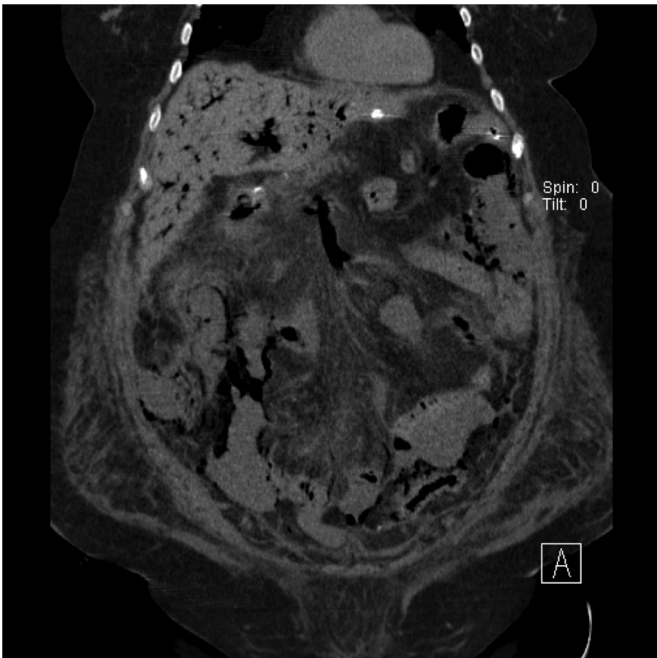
Coronal view of abdominal/pelvic CT scan showing extensive gas in the superior mesenteric vein.
